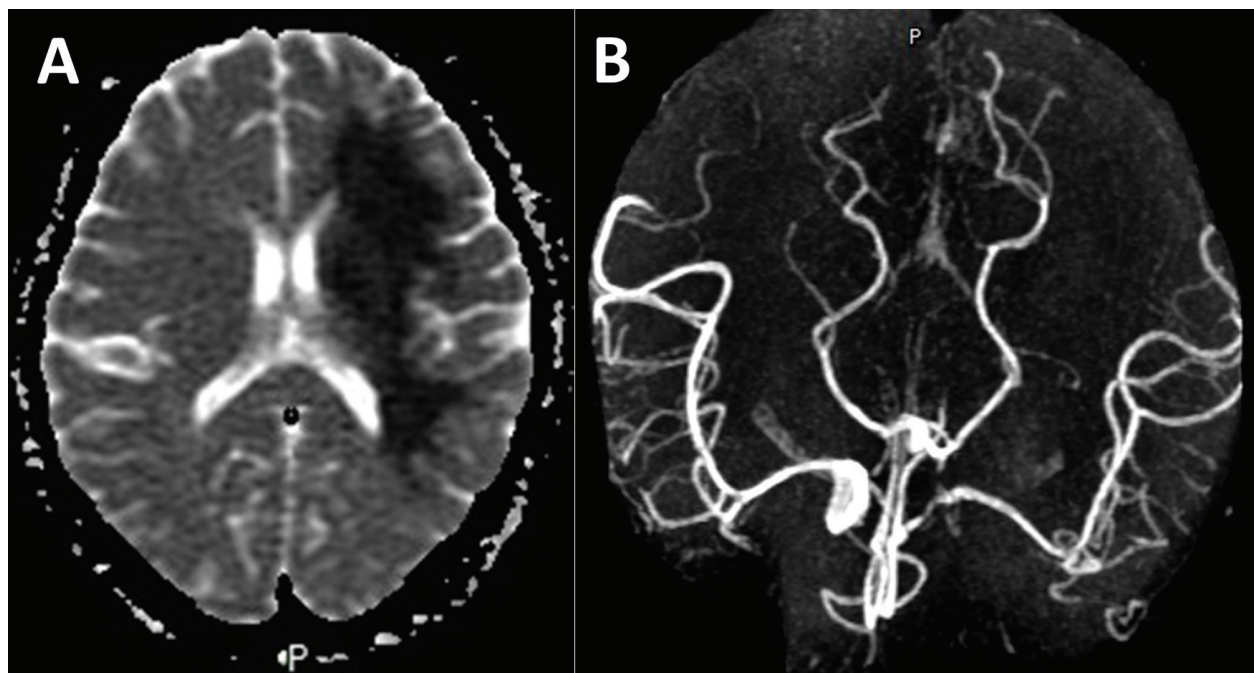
(A) Brain MRI reveals a low ADC (apparent diffusion coefficient) signal at the left MCA territory, indicating a left MCA ischemic infarct. (B) Brain MRI TOF MRA shows no occlusion at the left MCA.
